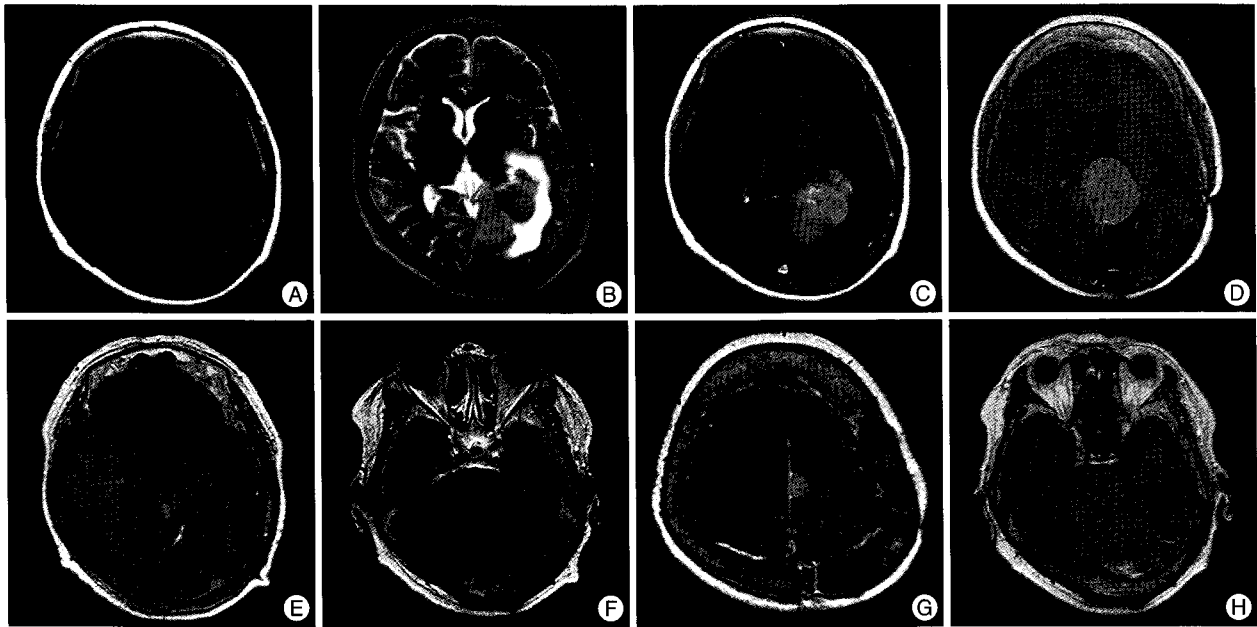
MRI is showing a large mass in the trigone of the left lateral ventricle. The tumor shows iso-signal intensity on T1WI (A), high-signal intensity on T2WI (B), and homogeneous strong enhancement (C). Enhanced T1WI at the recurrence is showing that the tumor is extending into the ipsilateral quadrigeminal cistern, contralateral occipital lobe and is compressing splenium, thalamus (D). The new local distant metastatic lesions in the left occipital (E) and left cerebellar cortical area (F) and progression of a small mass attached to the falx (G) are identified on enhanced T1WI performed about 24 months after the recurrence. All the lesions are increasing in size gradually and a new enhancing lesion is found in the fourth ventricle on enhanced T1WI (H). MRI : magnetic resonance imaging, WI : weighted image.
